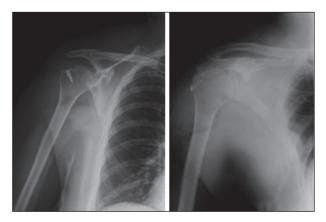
post-operative X-Ray: anchor vs. Sharc-ft
